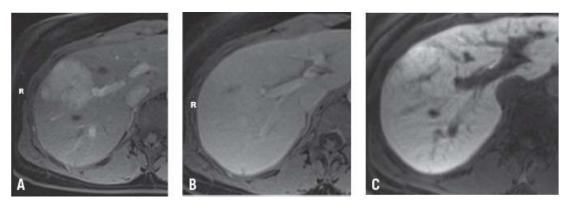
Focal nodular hyperplasia (FNH). Arterial phase hyperenhancement (A) and equilibration during portal venous (B) or later postcontrast phases, along with retention of contrast similar or brighter than the background liver during the hepatobiliary phase (C), are classic features of FNH. MRI performed with hepatobiliary contrast agents can provide definitive diagnosis of FNH.
